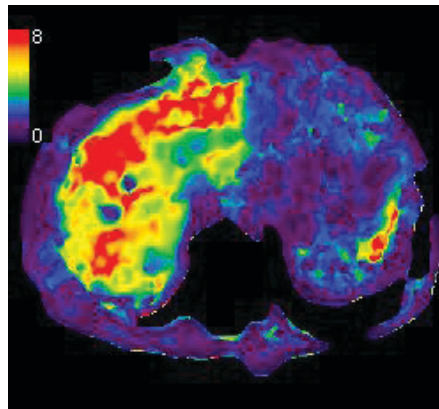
MRI with elastogram.
